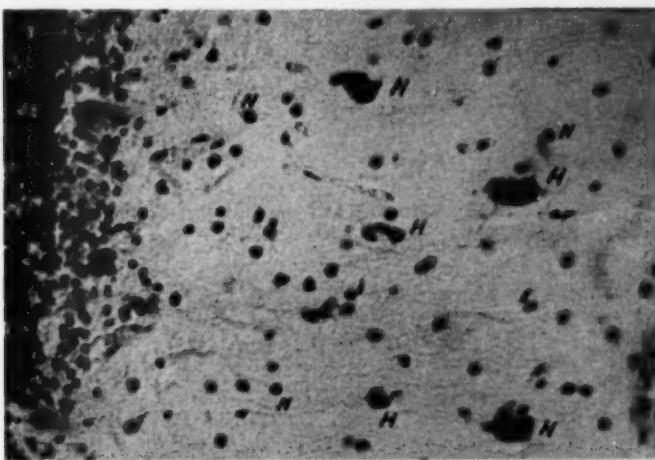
Hypertrophy of the glial cells in the molecular layer of the cerebellum of a patient who had received a course of x-ray therapy some 15 months prior to death. Internal granule cell layer and Purkinje cells on left side. Hypertrophied glial cells (H) in molecular layer. Normal glial cells (N). Weil-Van Gieson preparation; $\times 430$.
